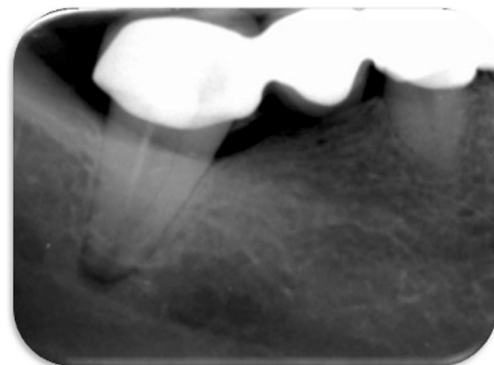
Case #2 initial radiograph of the tooth #47 demonstrating the absence of apical constriction due to inflammatory resorption, the AP and the proximity to the mandibular nerve
